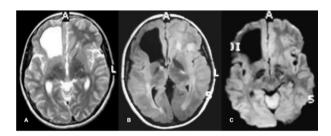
Axial MRI of the brain. A-B: T2-weighted & FLAIR images showing diffuse high signal intensities in the cortical and deep frontoparietal peri-ventricular regions. A large frontal porencephalic cyst, probably caused by an old infarct, can be seen as well. C: DWI image of the brain showing restricted flow in the abovementioned areas.
